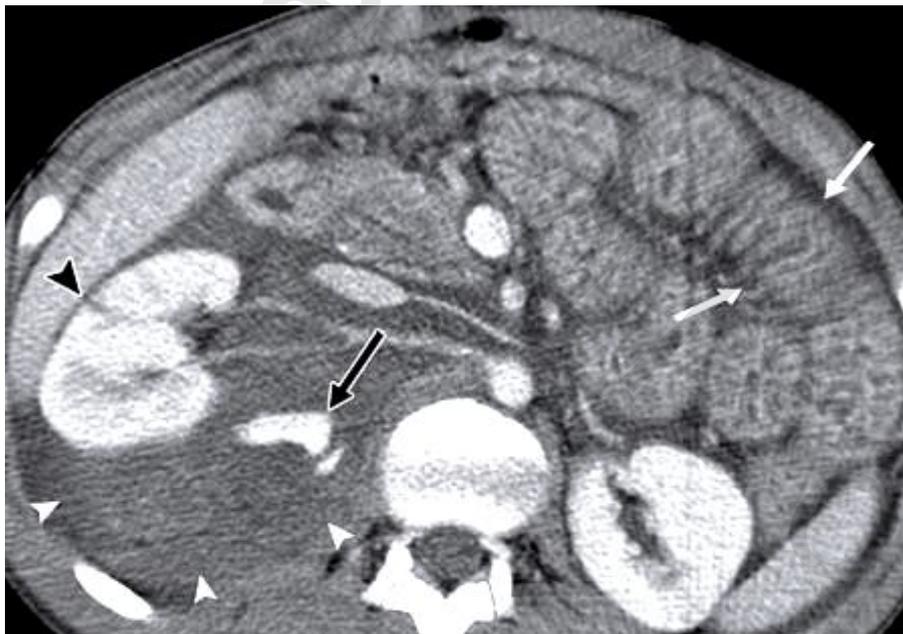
Contrast-enhanced CT scan shows right-sided perirenal and posterior pararenal retroperitoneal hematoma (white arrowheads) from a right renal laceration, with active extravasation of intravascular contrast material (black arrow) from a renal parenchymal injury. A laceration of the right kidney is also visible (black arrowhead). Hyperenhancing, thickened small bowel (white arrows) due to shock.
